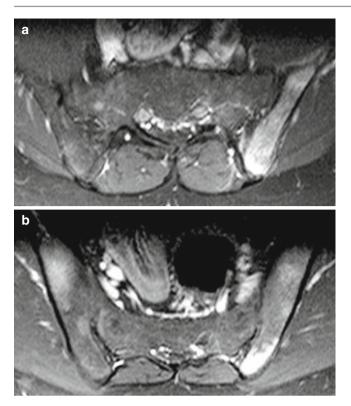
Axial SE T1-weighted images with fat saturation following the administration of contrast medium (a, b): asymmetric acute inflammation of both joints (b), more evident on the left (a-b)
